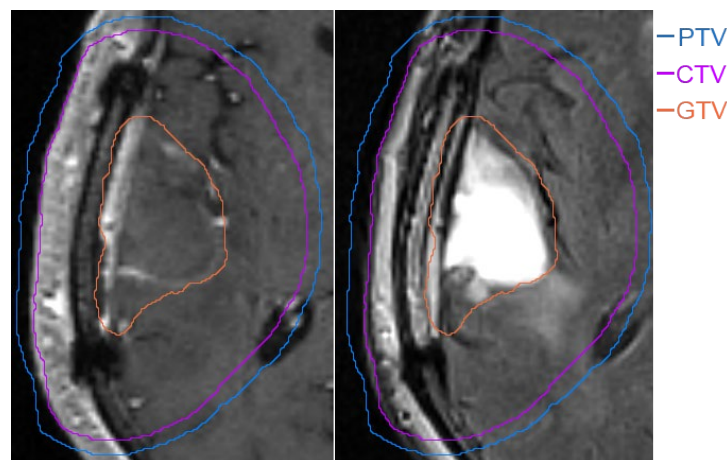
Example of “classical” target volumes GTV, CTV, PTV on one axial MR slice of the brain; left) T1-weighted image with gadolinium enhancement; right) FLAIR sequence
